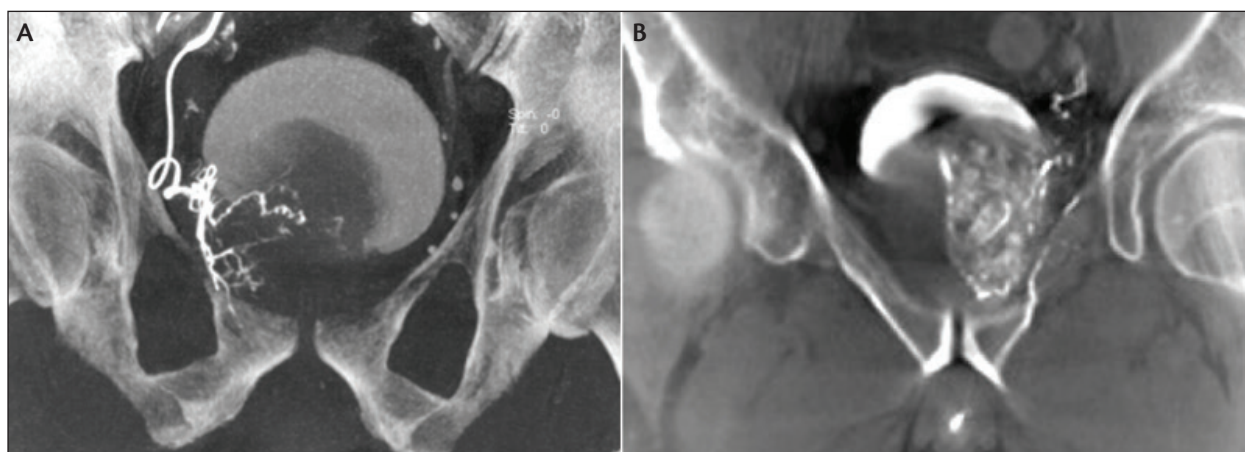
CBCT maximum intensity projection showing a type III origin prostate artery off the obturator on the right (A). Left lobe of the prostate on a 3-mm-slice thickness multiplanar reconstruction CT-like image after superselective left prostate artery injection (B).
